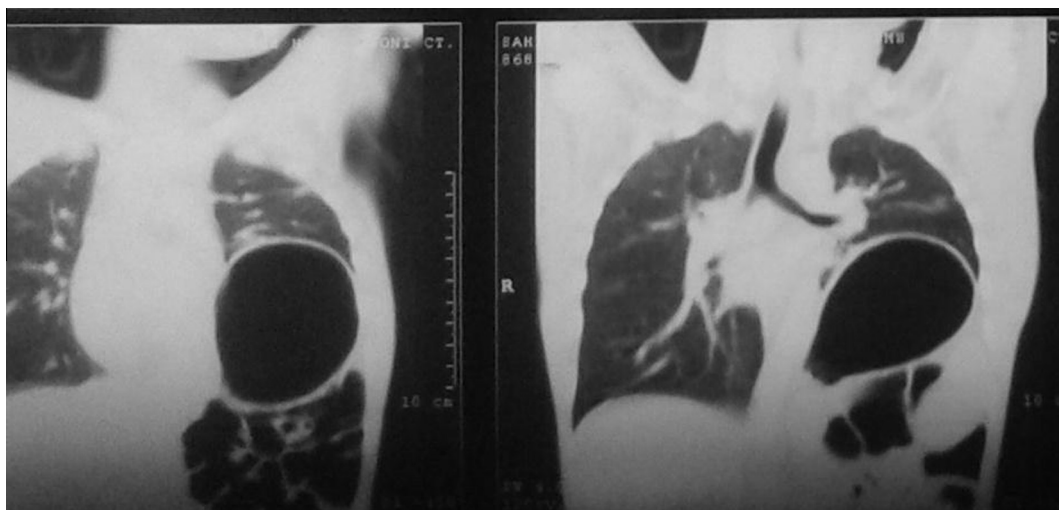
CT chest coronal section showing the eventration of the diaphragm.
